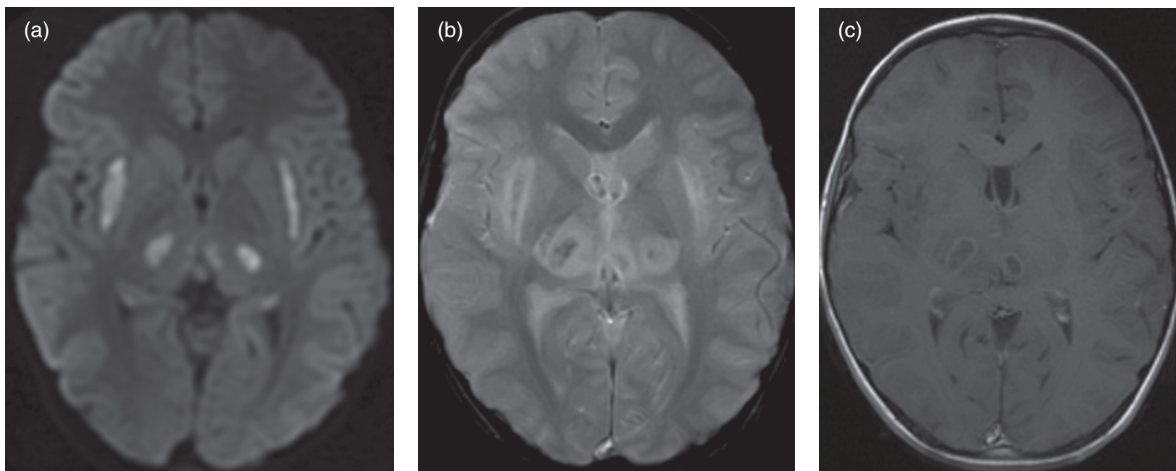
Acute necrotizing encephalitis in a patient with febrile illness, encephalopathy, and gait changes. (a) Axial diffusion imaging demonstrates cytotoxic edema in the claustrum and thalami, accompanied by petechial hemorrhage (hypointensity) on (b) the axial T2* gradient echo sequence, sensitive to magnetic field disturbances. (c) MRI T1 axial image with contrast. The thalamic lesions demonstrate ring enhancement, consistent with necrosis.
